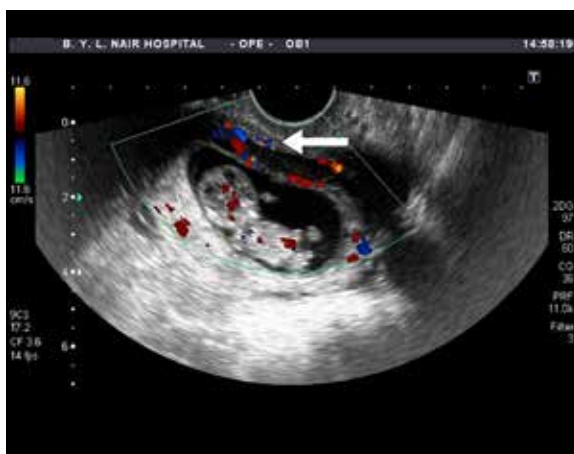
Transvaginal ultrasound with colour Doppler reveals an area of peripheral vascularity around the gestational sac (solid white arrow). Cardiac activity is noted in the form of colour fill in the foetus indicating a live pregnancy.
